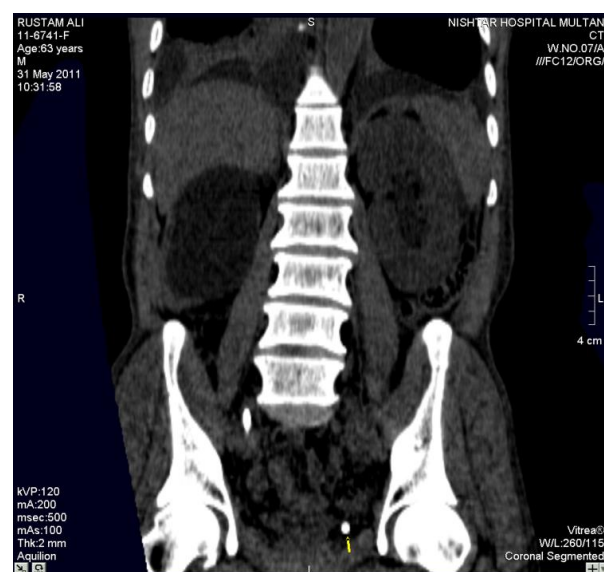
CT scan –Bilateral ureteric calculi with hydronephrosis
